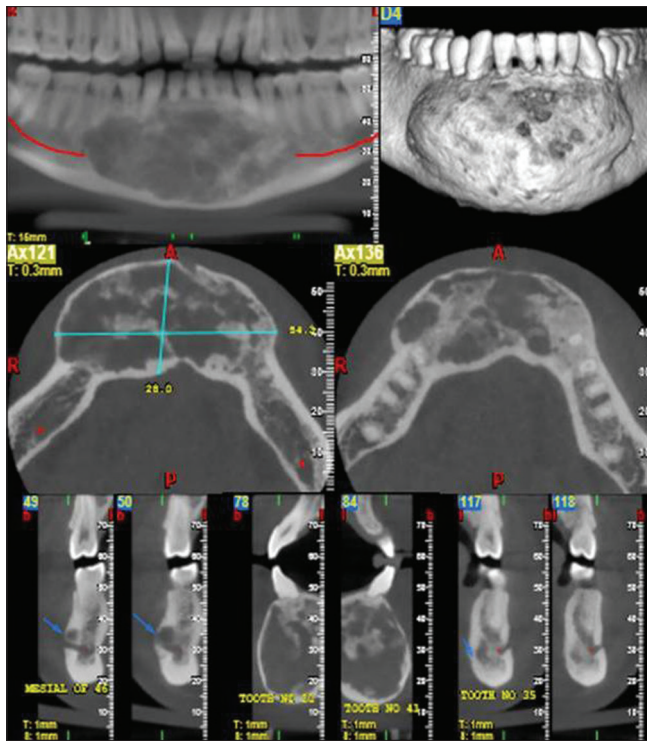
Cone beam computed tomography size of the lesion along with osteoblastic activity resulting in formation of the lost bone at the inferior border of mandible
